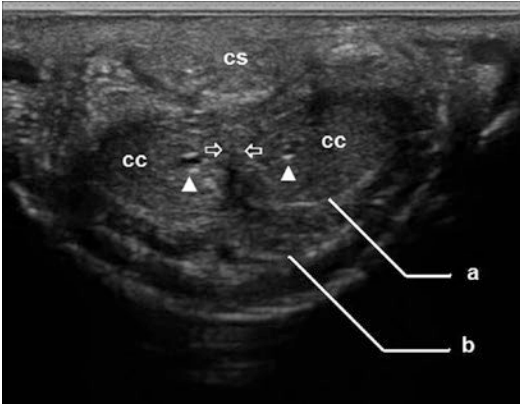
Normal gray-scale ultrasound anatomy. Axial scan on the ventral aspect of the penis showing the paired corpora cavernosa (*cc*), the corpus spongiosum (*cs*), the penile septum (*open arrows*), the tunica albuginea (a), the Buck's fascia. And the cavernosal arteries (*arrowheads*)
